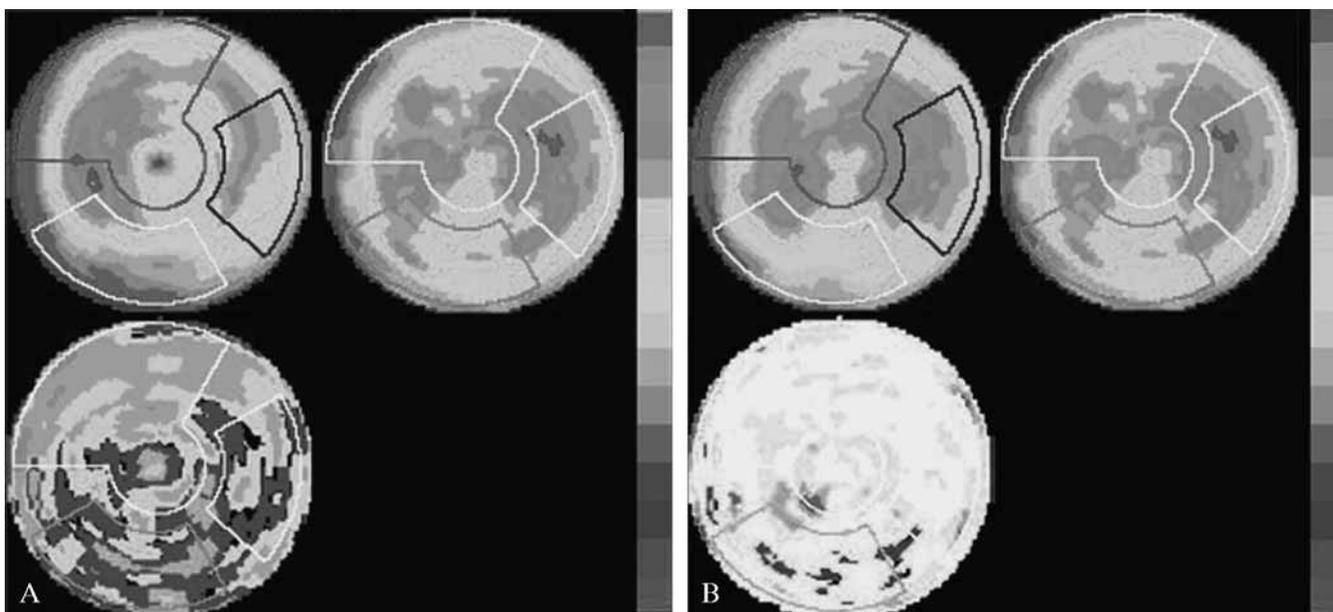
Example of UR calculation: top left: stress polar map, top right baseline resting polar map; bottom left UR polar map. A) Dipyridamole SPECT showing uptake defects in all coronary artery territories; B) dobutamine SPECT showing an inferior defect only. The more positive UR and the greater contrast in dipyridamole versus dobutamine UR polar map are apparent. In the color scale red=highest activity (or most positive UR), magenta=lowest activity (or most negative UR).
